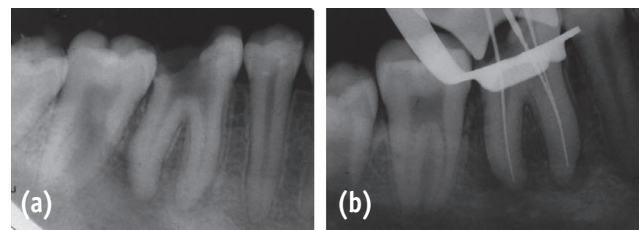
(a) Radiograph confirming instrument removal; (b) Working length reconfirmed.
